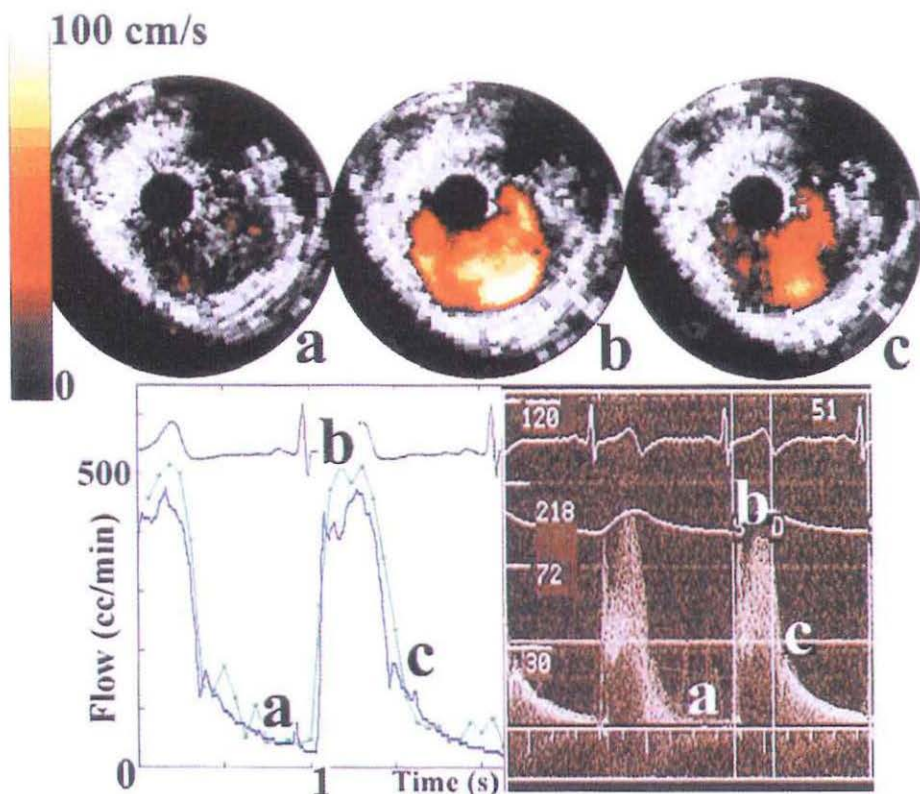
Image and local colour-coded blood velocity yielding volume flow during various phases of the cardiac cycle (a, b and c) with corresponding Doppler recording (bottom).
